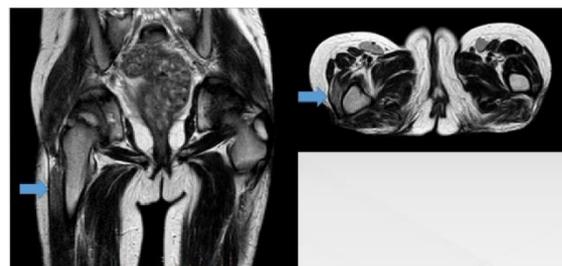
These are coronal and axial T2W MR images of hip at the level of proximal femur which showed hyperintensity in the proximal part of right vastus lateralis muscle.
